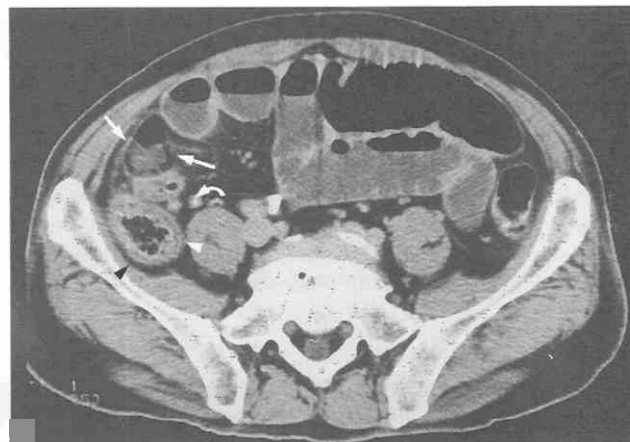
Bowel infarct caused by mesenteric arterial embolic occlusion with iodinated poppyseed oil (Lipiodol) after hepatic arterial embolization for hepatocellular carcinoma. CT scan shows concentric bowel wall thickening of the ileum with intestinal pneumatosis (arrows). The wall of the ascending colon is also thickened (arrowheads). A hyperattenuated Lipiodol (curved arrow) occludes the ileocolic branch of the superior mesenteric artery. (From Rha SE, Ha HK, Lee SH, et al: CT and MR imaging findings of bowel ischemia according to the various primary causes. *Radiographics* 20:29–42, 2000.)
